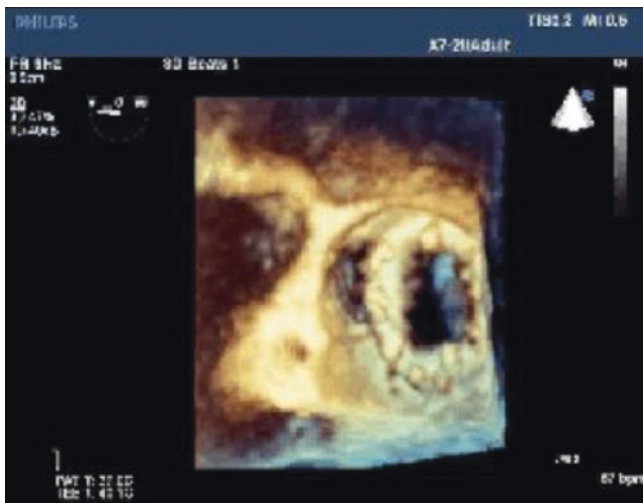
Dehiscent mitral prosthesis seen by 3D transesophageal echocardiography
